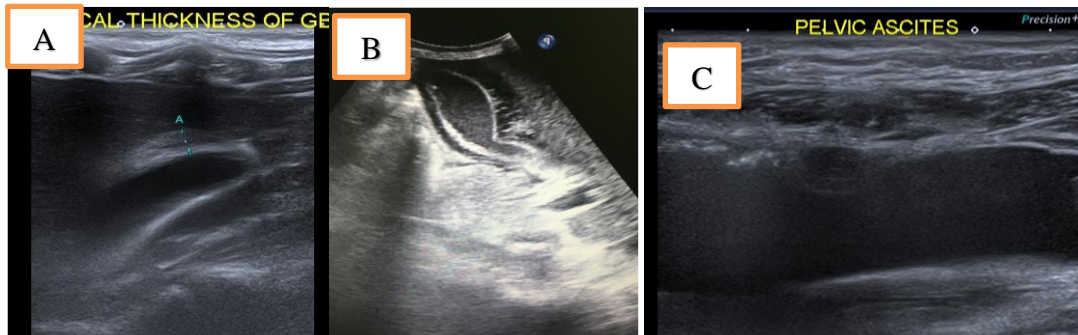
(a) shows focal GB wall thickening, (b) showing pericholecystic fluid, (c) pelvic ascites and (d) shows Percentage wise Abdominal Ultrasound Findings
